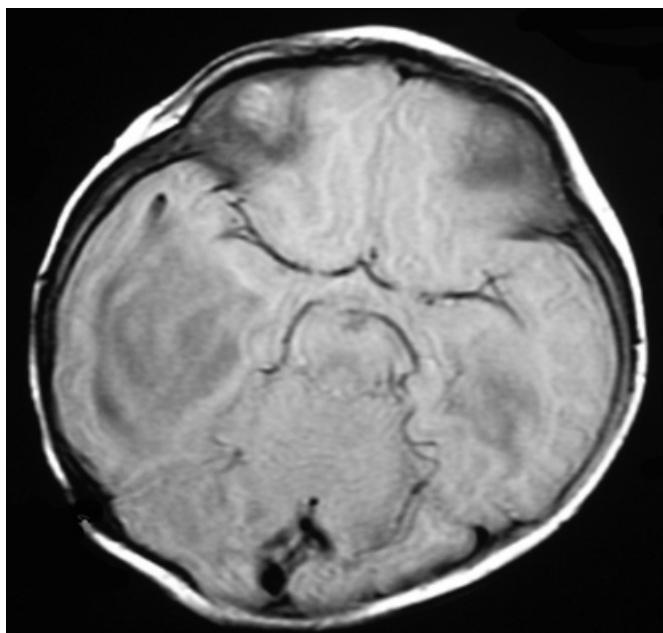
Proton density image of patient's brain MRI demonstrates normal right MCA and its distribution. This image has been provided at the same level of axial view of Figure 2.
